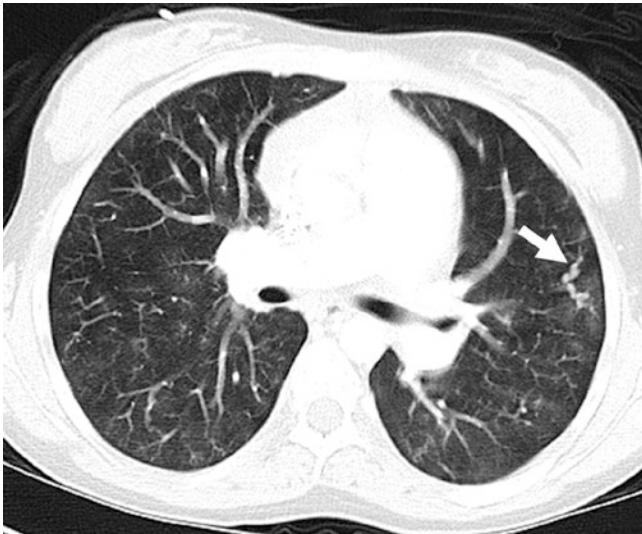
Sixteen-year-old girl with idiopathic pulmonary hypertension who presented with shortness of breath. Axial lung window CT image demonstrates enlarged and tortuous peripheral pulmonary vessels (arrow)
